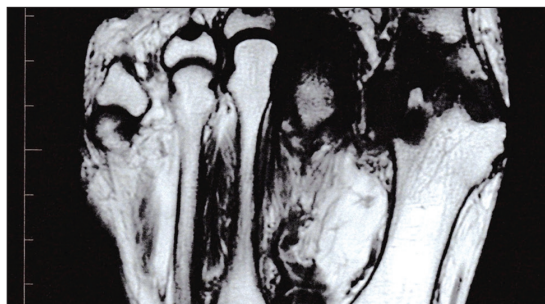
MRI of the foot demonstrating gouty tophus with erosions of the first MTPJ and phalanx.
